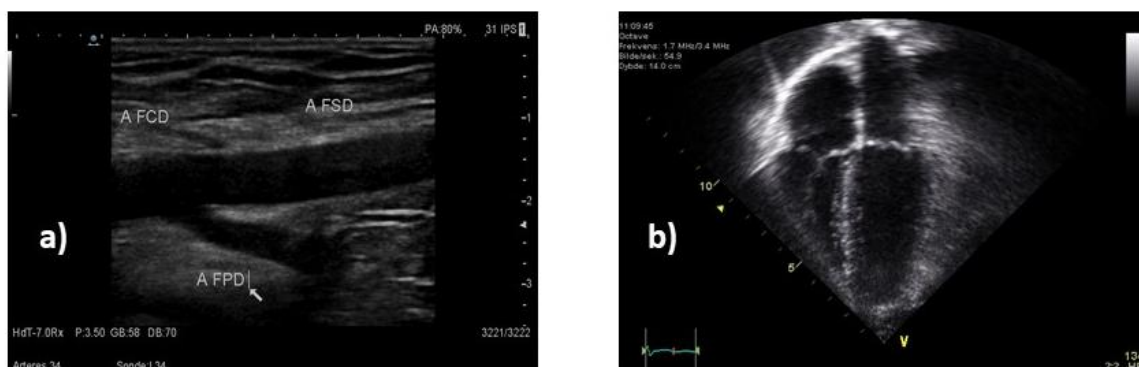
Conventional ultrasound images: a) division of the common right femoral into the superior and posterior femoral arteries [Courtesy of Pr. Anne Long, Hôpital Edouard Herriot, Lyon, France] ; b) Echocardiogram four chambers.
